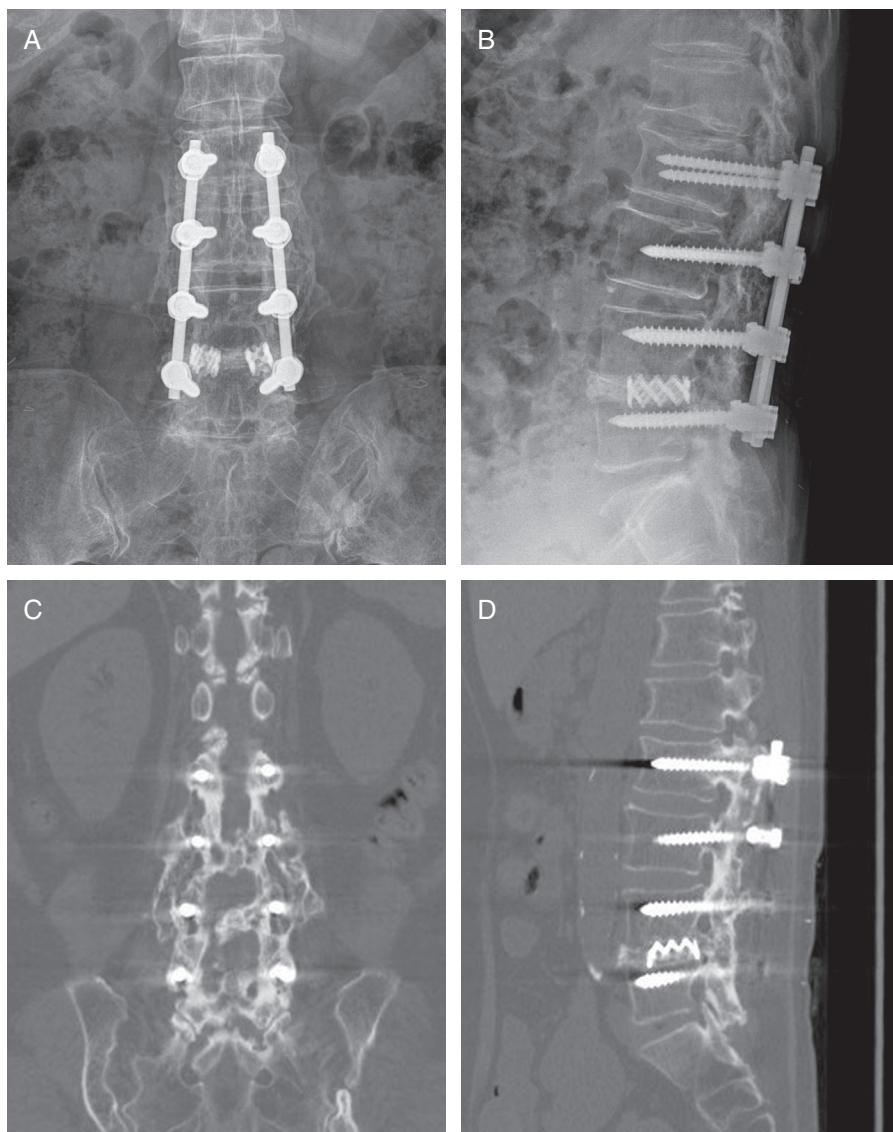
(A) Preoperative lumbar anteroposterior and (B) lateral plain radiographs. Preoperative lumbar three-dimensional computed tomography scans showing solid fusion from L2 to L5: (C) coronal view; (D) sagittal view.
